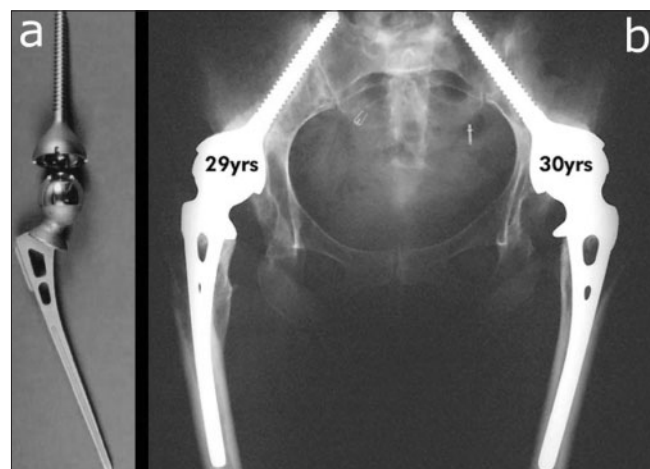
(a) A metal-on-metal (Ring) total hip replacement revised 23.5 years after implantation. It showed a femoral head linear wear of 10 μm (0.43 μm/year) and socket wear of 8 μm (0.35 μm/year). (b) X-rays of a patient with two well-functioning Ring THR, 29 and 30 years after operation, respectively.
